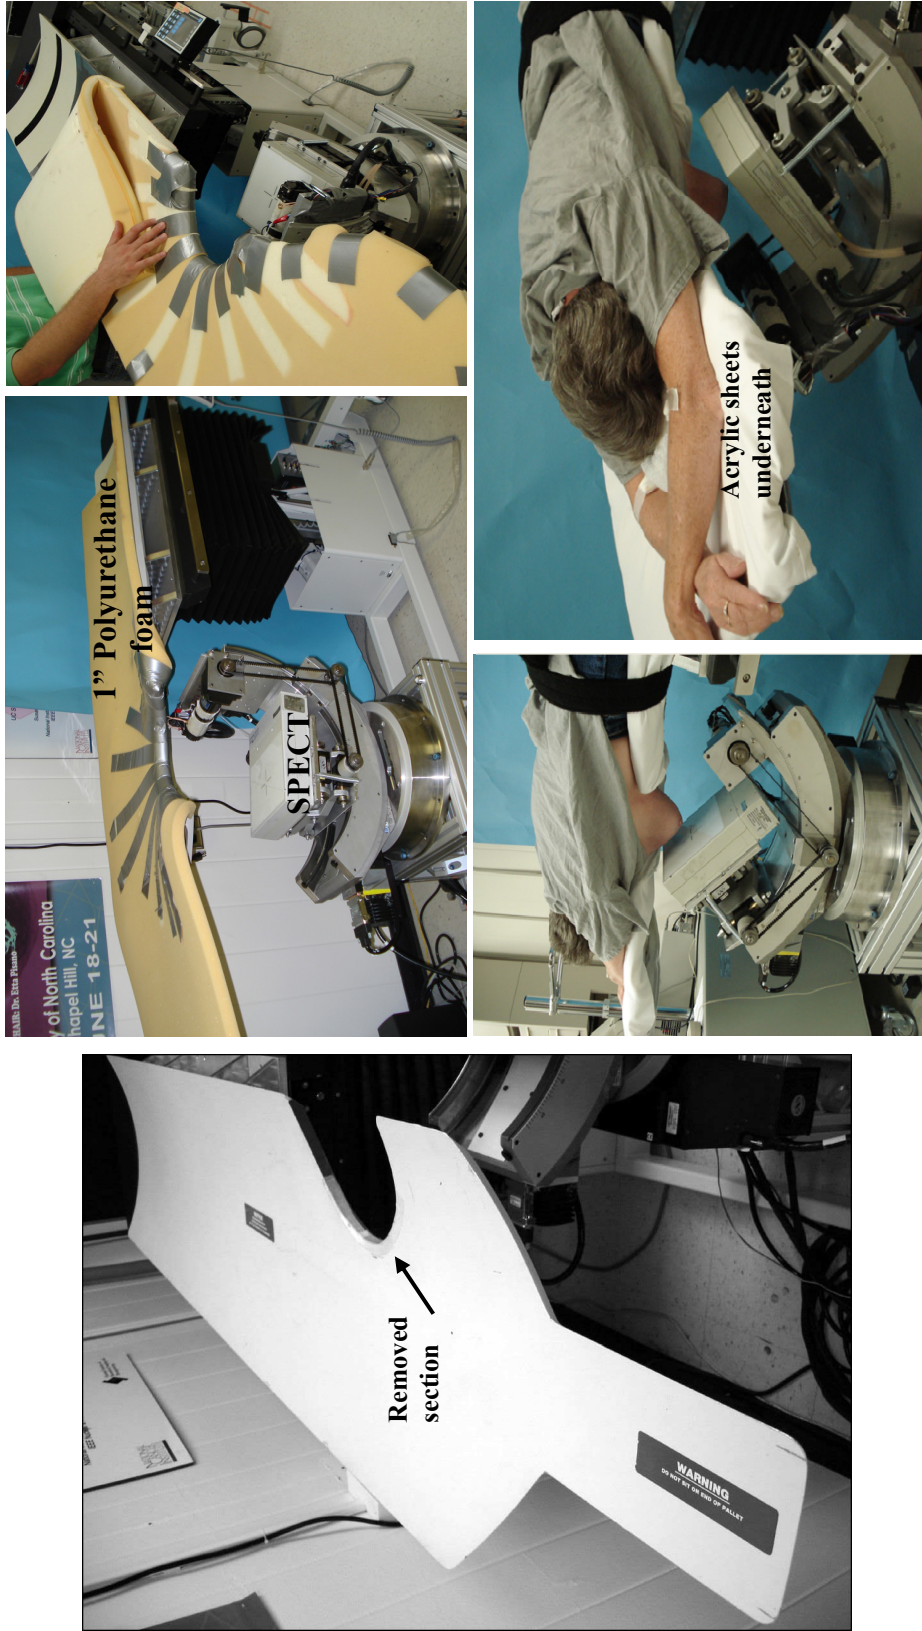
(Left) A photograph of the nuclear medicine bed palette prior to adding layers for the prone patient. The section removed from the side of the bed for imaging is shown. (Upper right) The lead-lined bed (the lead lining is not visible under the foam) is then shown with the layer of foam on the upper surface. (Lower right) The first patient volunteer lies prone on the bed while the SPECT system acquires data underneath her breast.
